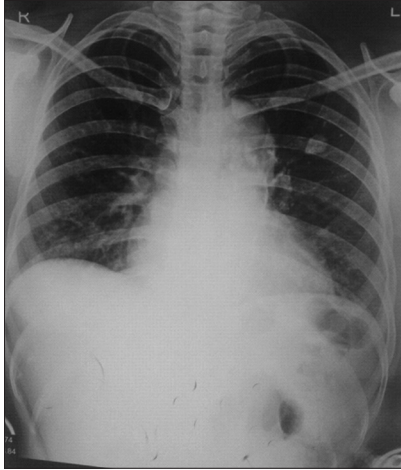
Chest X-ray showing mediastinal widening and few calcified parenchymal lesion in the left lower zone
